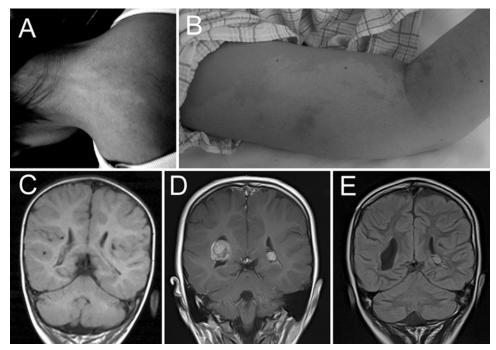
Features of the patient's skin and brain MRI studies. A and B: Sharply demarcated, hypopigmented streaks are seen in a linear pattern on the neck and right arm. C: Coronal T1-weighted image obtained 4 years prior to the operation, demonstrating the absence of tumor. D: Coronal Gd-enhanced T1-weighted image showing bilateral intraventricular tumors. E: Coronal FLAIR image demonstrating total resection of the left ventricle tumor and no tumor recurrence. The right ventricle tumor remains unchanged.
